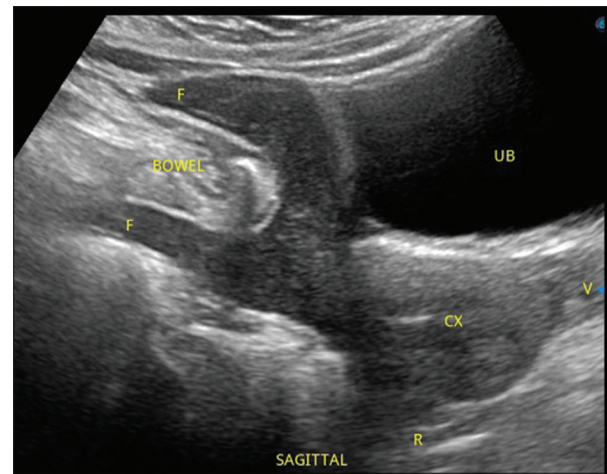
Transabdominal sonogram showing the urinary bladder, vagina, and rectum are intact. The cervix measures 3.0 cm × 2.7 cm × 3.0 cm with distinct endocervical canal. The uterus is anteverted with irregular contour and homogeneous echo pattern measuring 8.0 cm × 7.9 cm × 4.9 cm with a defect at the fundal area, more to the right measuring 2.0 cm. A hyperechogenic structure measuring 4.0 cm × 2.4 cm (l × h) demonstrating peristalsis suggestive of a segment of bowel (BOWEL) is seen insinuating into the defect. UB: Urinary bladder, CX: Cervix, R: Rectum, V: Vagina, F: Fundal
